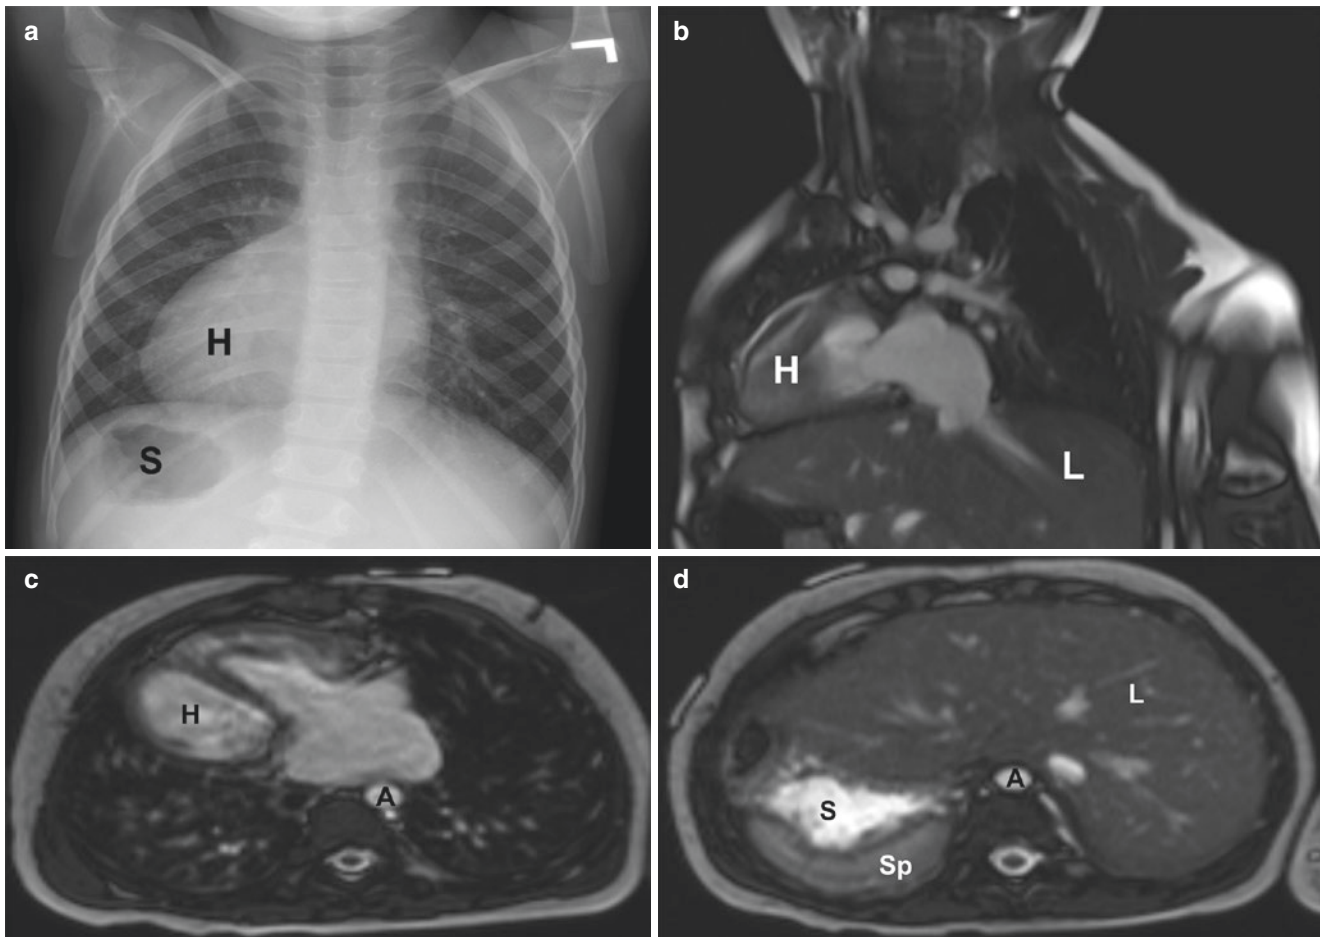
Heterotaxy syndrome in a 4-year-old girl. (a) Frontal chest radiograph shows a right-sided heart (H) and stomach (S). (b) Coronal oblique non-enhanced bright-blood MR image shows right-sided heart (H) and left-sided liver (L). (c) Axial non-enhanced bright-blood MR
